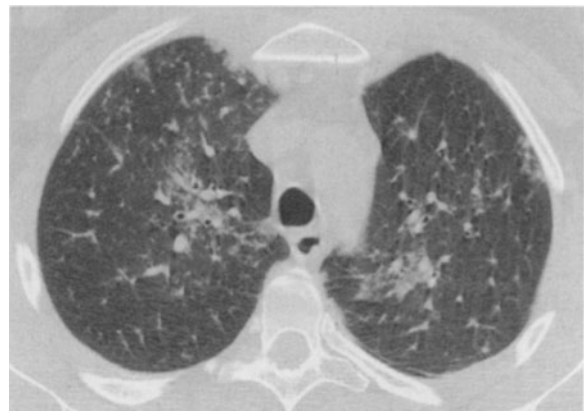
A 42-year-old woman with AIDS presenting with "asthma" and diarrhea. *Strongyloides stercoralis* was present in sputum and stool. Chest CT at the level of the aortic arch demonstrates small nodules and patchy areas of ground glass opacity bilaterally
